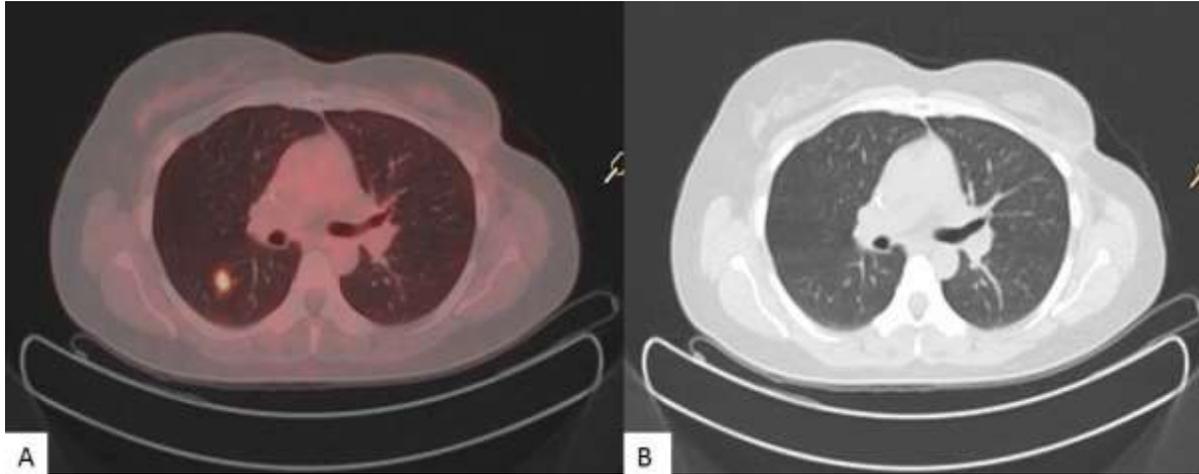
Fused FDG PET CT showing focal FDG uptake in right lung (A) but corresponding CT images does not show any structural abnormality (B)
